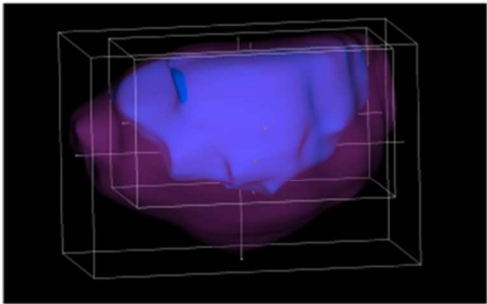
An example of the 3D Slicer ROI tool surrounding the prostate capsule (magenta) and central gland (blue) of study subject. This ROI tool is used to find the tri-axial dimensions of the prostate, in both the ultrasound and MR image datasets.
